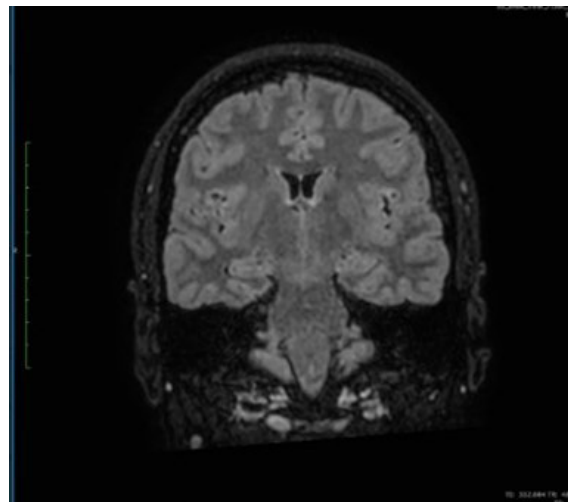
GADOLINIUM-ENHANCED BRAIN MRI SHOWING BILATERAL HYPERINTENSITIES IN THE TEMPORAL LOBES, HIPPOCAMPUS, AND INSULAR REGION, CONSISTENT WITH LIMBIC INFLAMMATION IN THE CONTEXT OF ANTI-NMDA RECEPTOR ENCEPHALITIS.
